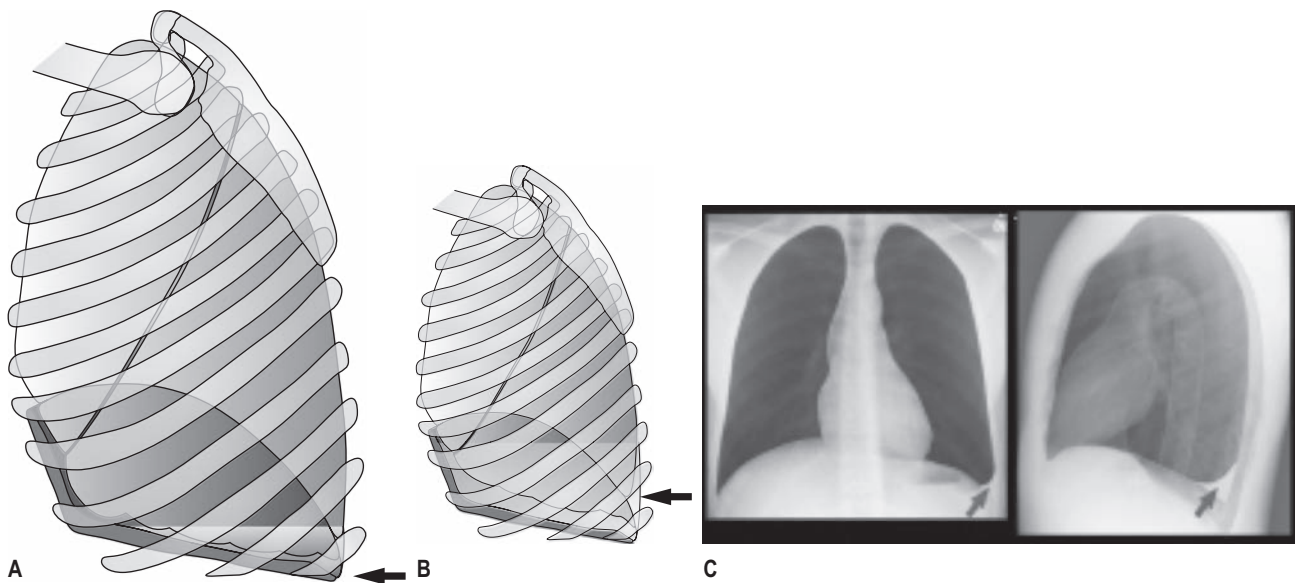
(A) Small pleural effusion detected on lateral chest x-ray (arrow indicates the effusion). Larger pleural effusion (B). This can be visible on both the lateral and posteroanterior chest views (C) (arrow indicates the effusion).
